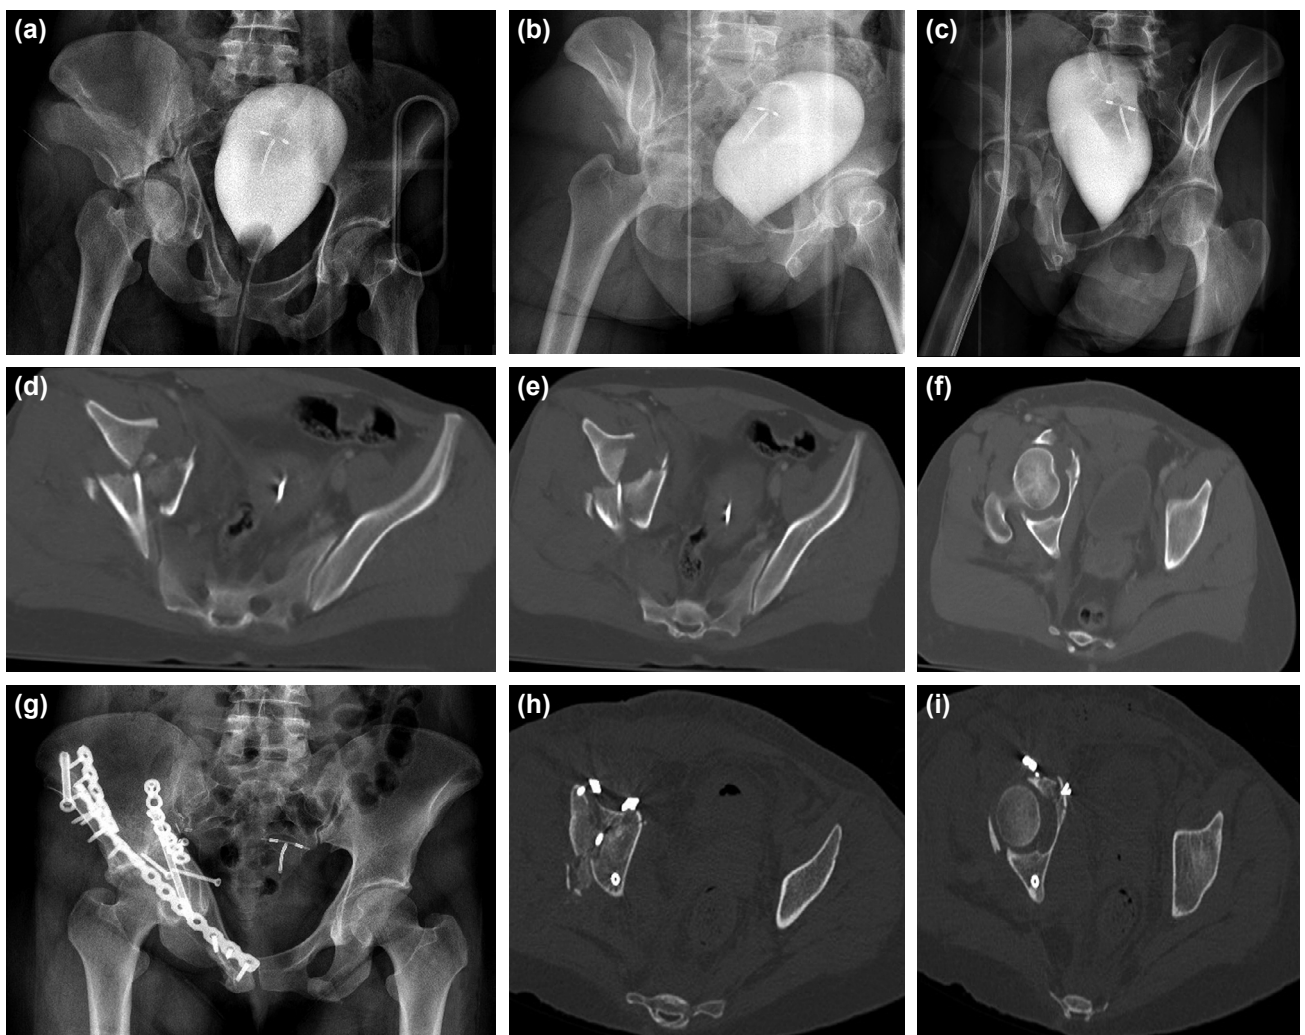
25 years-old female, motor vehicle accident. A-P pelvis (a) and Judet views (b, c). Preoperative computerized tomography scan shows both column fracture (d-f). Post-operative x-ray (g) and computerized tomography scan (h, i) show anatomical restoration of fracture.
